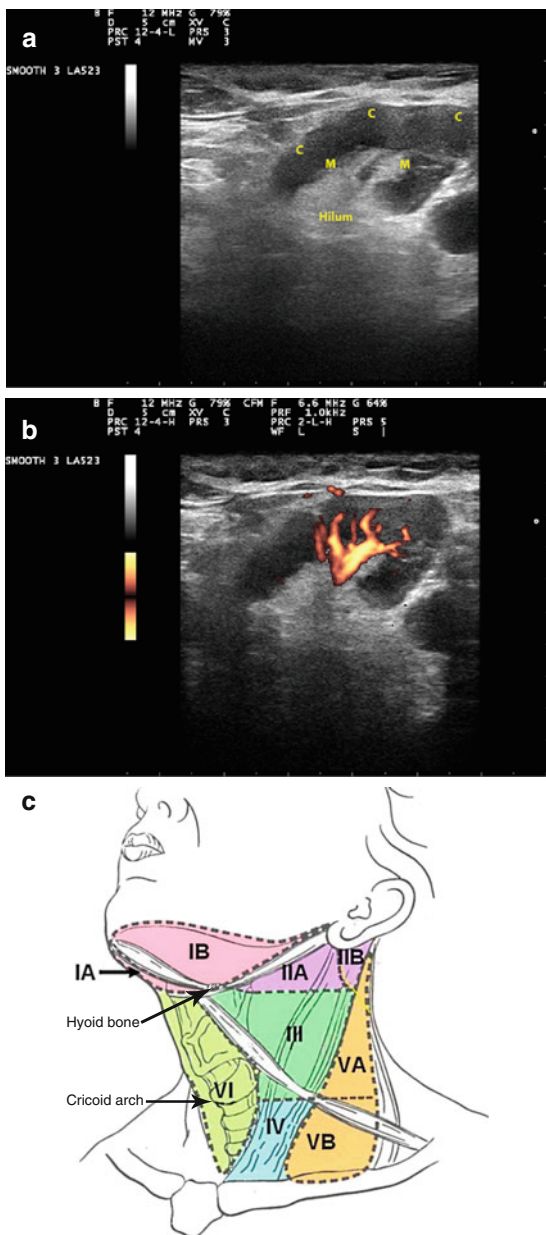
Ultrasound anatomy of a reactive lymph node showing cortex (C), medulla (M), and hilum (H) with a prominent vascular pole by Doppler examination (a, b). Anatomic levels of the neck (c)
